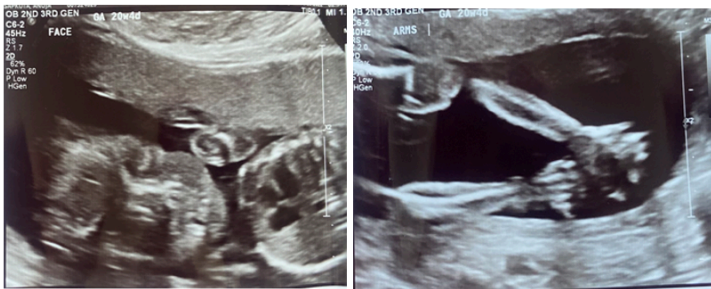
Ultrasound images of a fetus's face and arms during week 20.
